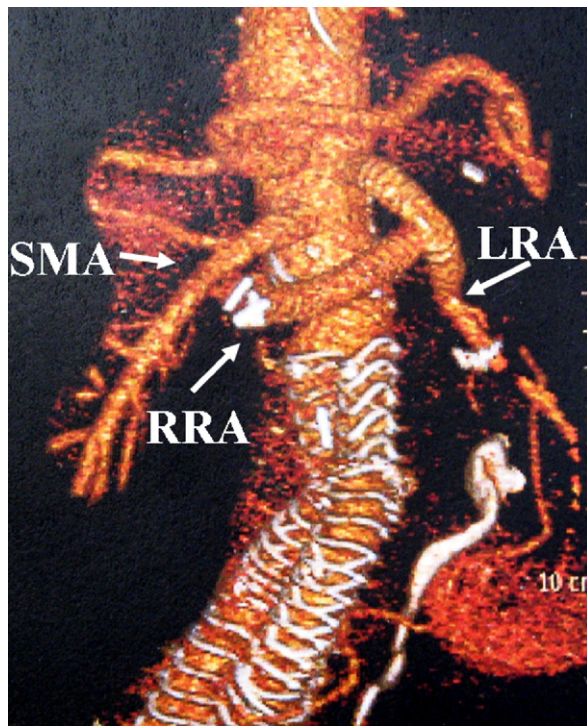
Postoperative 3-dimensional reconstructed computed tomography angiogram demonstrates the aortorenal artery bypass and the bifurcated endograft covering the origins of the renal arteries. *LRA*, Left renal artery; *RRA*, right renal artery; *SMA*, superior mesenteric artery.
